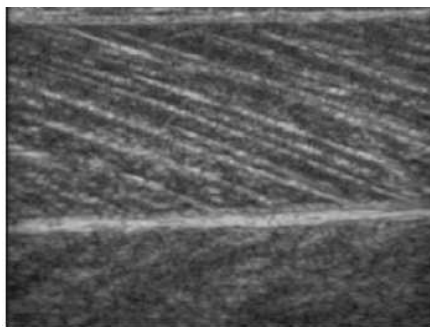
Example of a longitudinal ultrasonic image of the MG muscle of an healthy young male.
